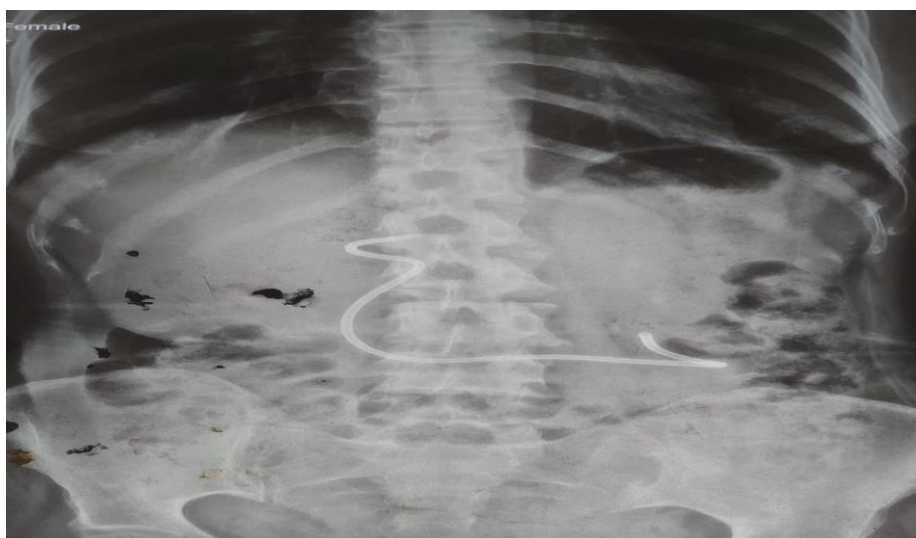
X-ray abdomen erect showing opaque shadow of stent
